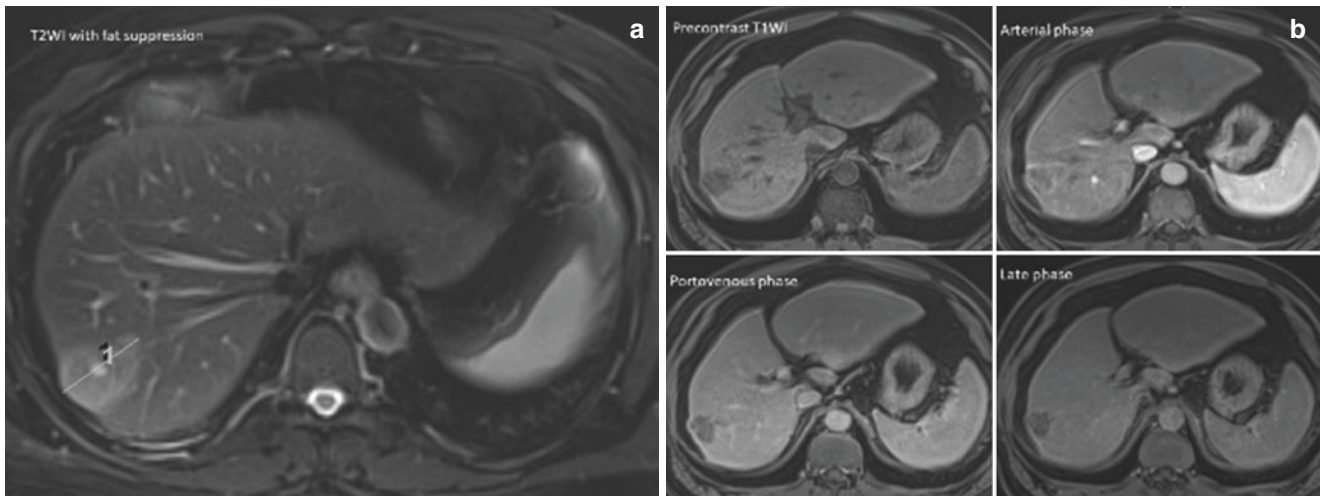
A 57-year-old male with cholangiocarcinoma at S7 of liver underwent Gd-DTPA-enhanced MR imaging. (a) The tumor is hyperintense on T2WI. (b) The tumor features hypointense on pre-enhanced
